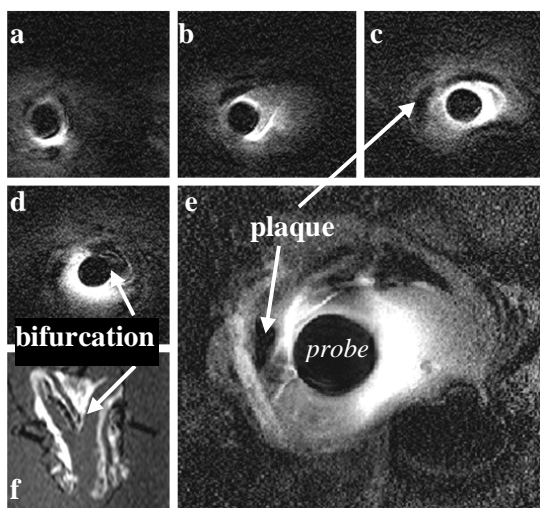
(a-d) 0.7fps MRI of human iliac in saline (TR/TE =13/3ms; 200 μ m). (e)Plaque from (c) at 100 μ m resolution. (f) Surface coil image near (d) showing bifurcation.
